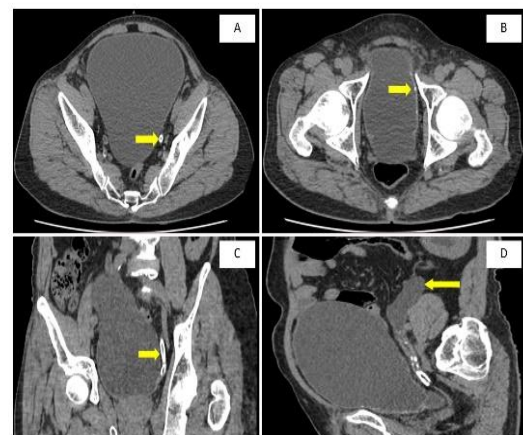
Non-contrast pictures of the CT urogram showing (circumferential calcification of ureteric walls (B) calcifications of the bladder wall (C) calcification of the ureteric wall (D) dilated left ureter proximal to the calcified lower segment
